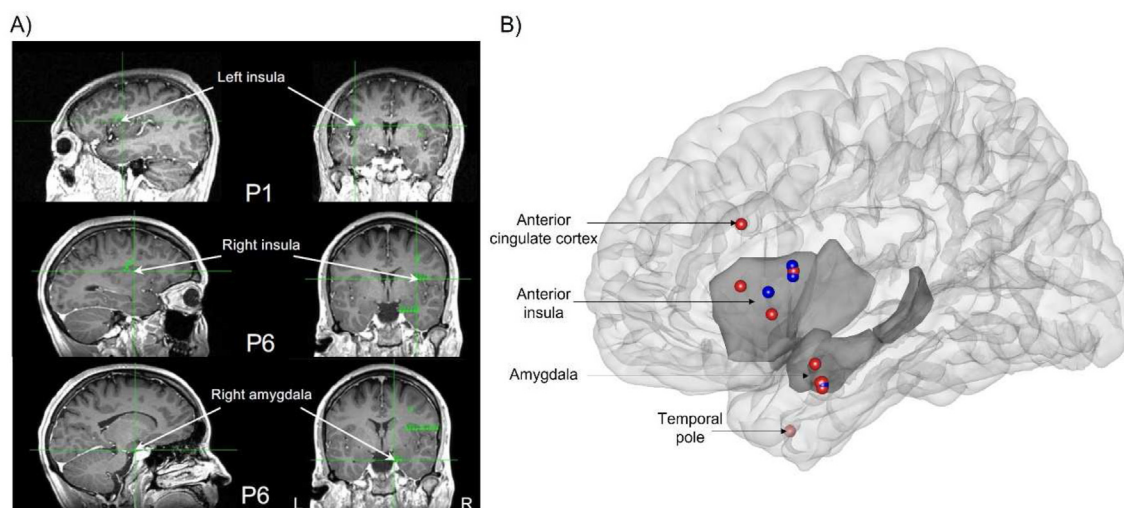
A) Example of localization and projection on patient's MRI of stimulated contacts inducing positive emotional sensations in some patients (GARDEL software. B) EBS sites are summarized by projection on the right hemisphere of the 3D mesh of the MNI normalized brain appended with meshes of amygdala and insula for better visualization. Colours indicate the lateralization these sites (blue = left side, red = right side).
